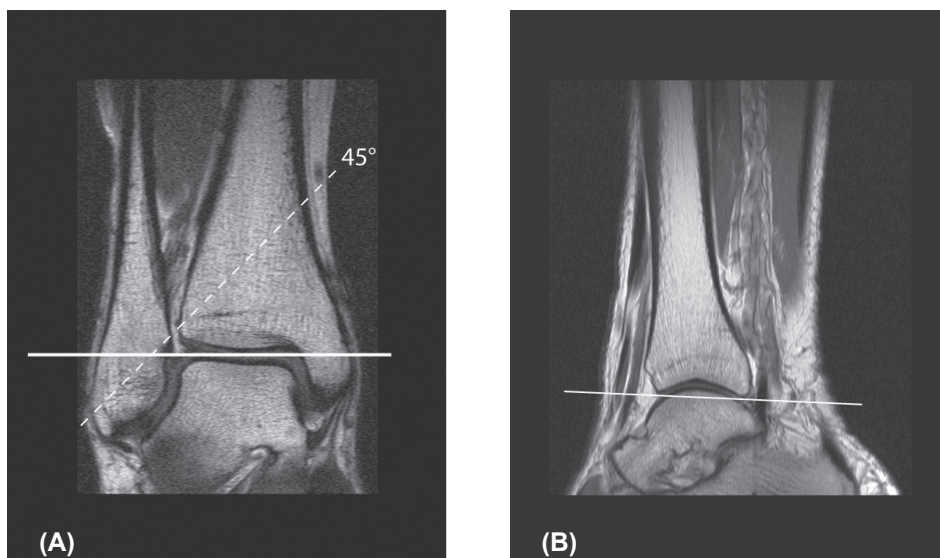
Coronal (A) and sagittal (B) MR image, which indicate the angle of the 45° oblique image plane for the anterior and posterior distal tibiofibular ligament. In the coronal plane the angle of 45° is related to the tibial plafond. In the sagittal view the direction of the oblique plane runs parallel to a line along the inferior border of the anterior and posterior tibia.
